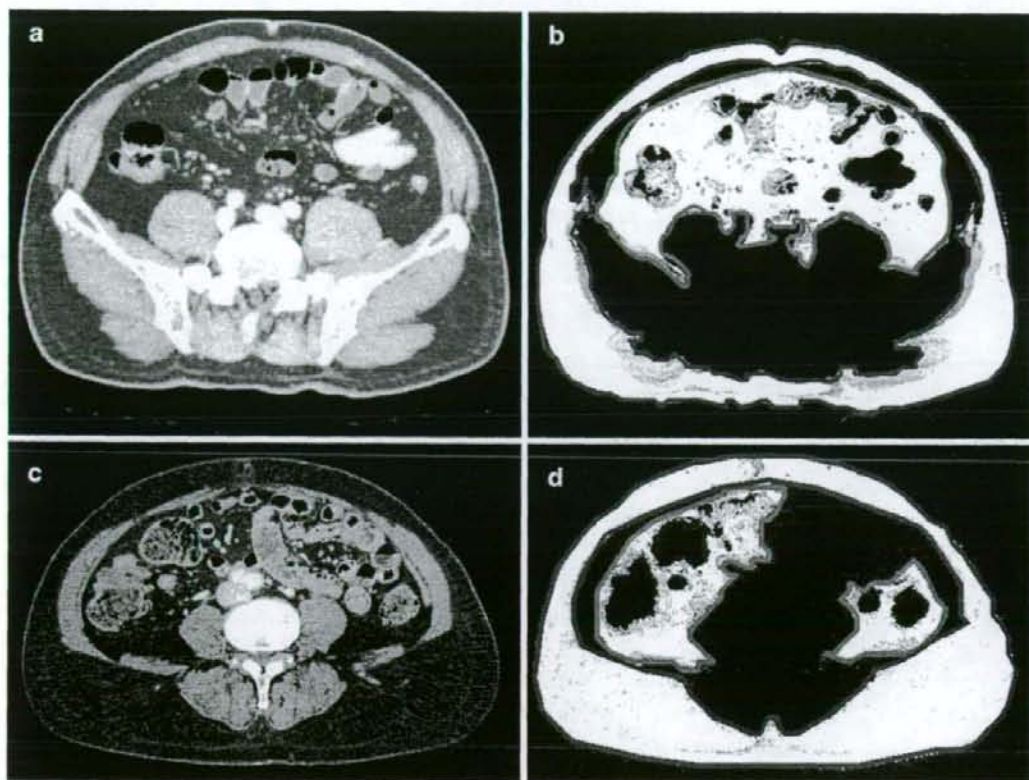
Images demonstrating a "viscerally obese" patient and a "subcutaneously obese" patient. A. Viscerally obese patient: original CT scan image. B. Viscerally obese patient: corresponding CT scan image with altered window width for the detection of adipose tissue. The visceral fat area is outlined by the red line, and the remainder is the subcutaneous fat area (between the 2 blue lines). Visceral fat area is 206.4 cm²; body mass index is 28.4 kg/m². C. Subcutaneously obese patient: original CT scan image. D. Subcutaneously obese patient: corresponding CT scan image with altered window width for the detection of adipose tissue. The visceral fat area is a sum of two components outlined by the red lines, and the remainder is the subcutaneous fat area (between the 2 blue lines). Visceral fat area is 106.8 cm²; body mass index is 28.3 kg/m².
